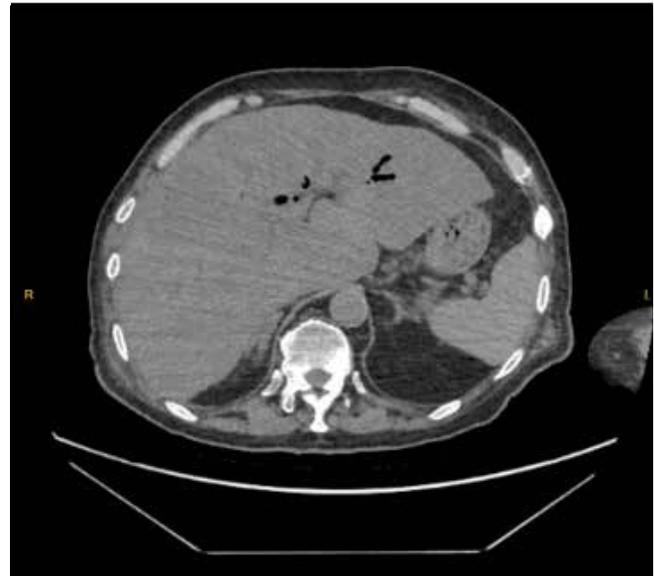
Air in the intrahepatic biliary tract at abdominal computed tomography. Portal vein cannulation usually occurs as a result of direct trauma to the papilla or mucosal and vascular laceration. In cases in which sphincterotomy was not performed, investigators have noted the portobiliary fistulas due to presumed tumor infiltration. Isolated portal vein cannulation has not been reported to result in mortality or serious morbidity. However, awareness of this rare complication is very important.
